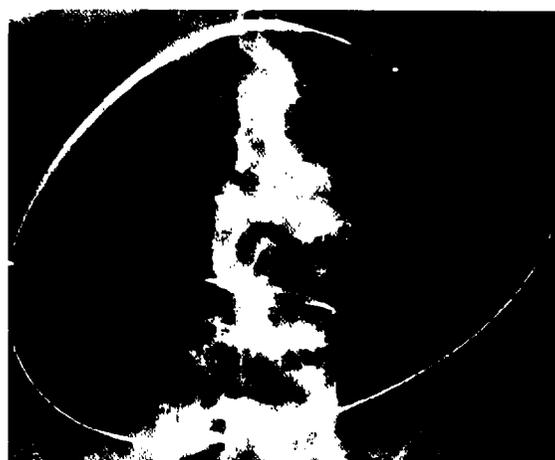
Wallstent delivery system placed in the stenoses, x-ray markers showing the distal and proximal stent position on the shaft
